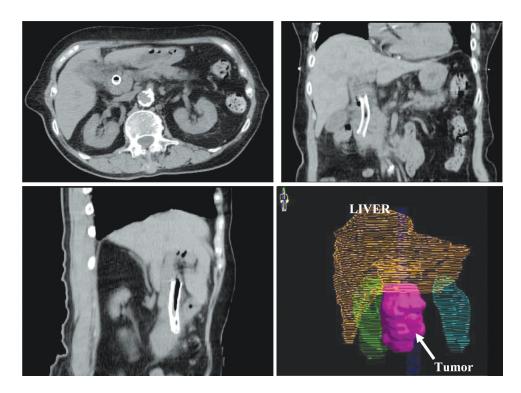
CT images show the tumor in 3 plane and 3 Dimensional imaging of tumor (pink colour), OAR Liver (yellow), right kidney (green), left kidneys (blue). There is metabolic stent placement in common bile duct.
